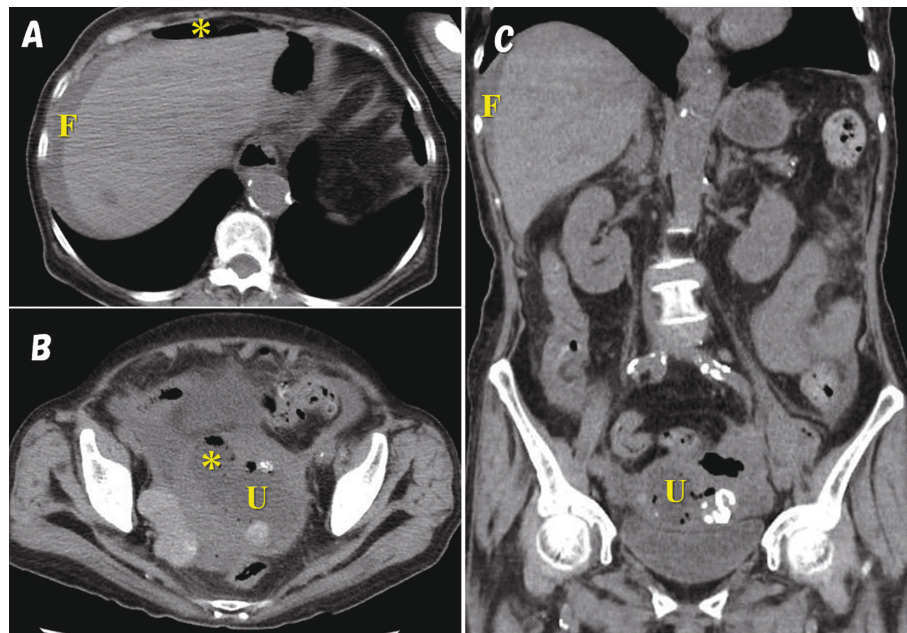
Preoperative computed tomography (CT) findings in Patient 1.
